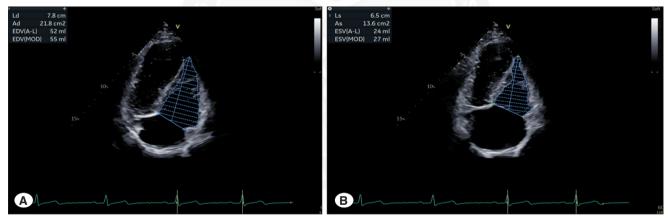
Three-dimensional (3D) echocardiographic assessment of right ventricular end- diastolic and end- systolic volumes (EDV and ESV) using model-based optimisation of dynamic imaging (MOD) (A,B).
